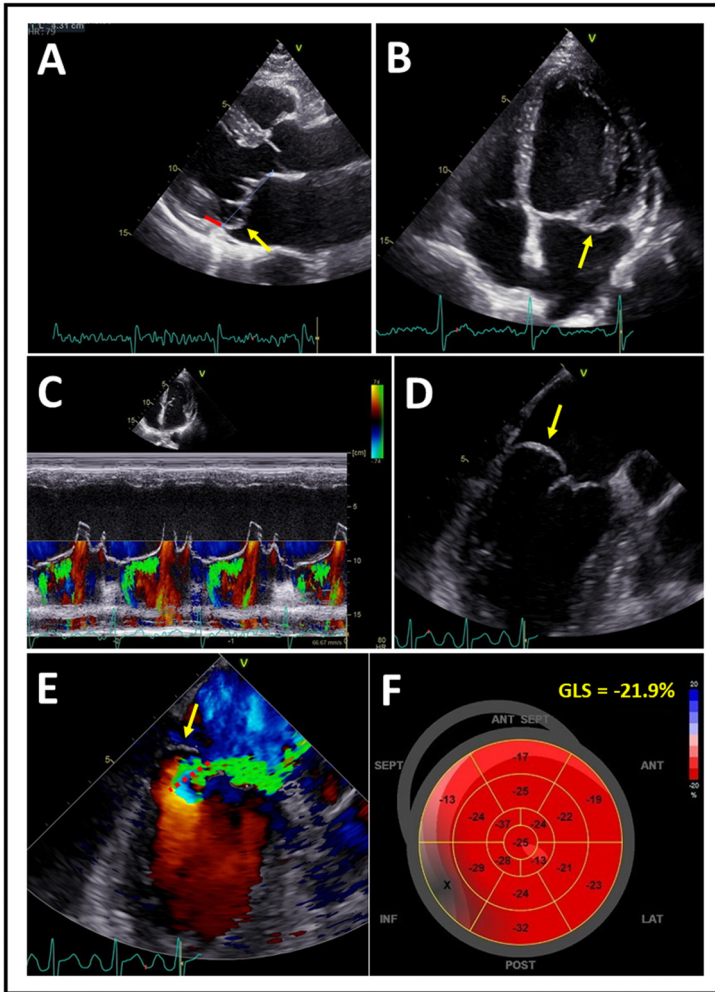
Echocardiographic images of a male patient in his 50s who presented with severe mitral regurgitation, posterior (P2) mitral valve leaflet prolapse and a Barlow-like mitral valve apparatus with dilated annulus. The referral physician at primary care noted a grade 3 systolic murmur without further detailed description. In particular, no mid-systolic click was noted. During a careful auscultation prior to mitral valve surgery, a grade 4/6 systolic murmur with late systolic peaking and blowing character best heard at the apex and radiating to the left axilla was noted. In addition, a clear mid-systolic click was noted. A is a parasternal long-axis and B apical 4-chamber view (both end-systolic frames) on transthoracic echocardiography, revealing a dilated left ventricle and a prolapse (systolic shift towards left atrium) of posterior mitral valve leaflet (arrows) and a mitral annulus disjunction with a distance of 13 mm (A, red line). C is color Doppler M-mode through mitral valve demonstrating a mid-late regurgitant jet with late systolic increase. D and E are long-axis view on transesophageal echocardiography showing billowing of posterior mitral valve leaflet (prolapse) towards left atrium (arrow), causing a severe eccentric mitral regurgitation with a proximal isovelocity surface area (PISA) radius of 1.3 cm (E, dotted red line). F is a Bull eye plot showing normal global longitudinal strain of -21%. 3D left ventricular ejection fraction was 69%. Color version of figure is available online.
